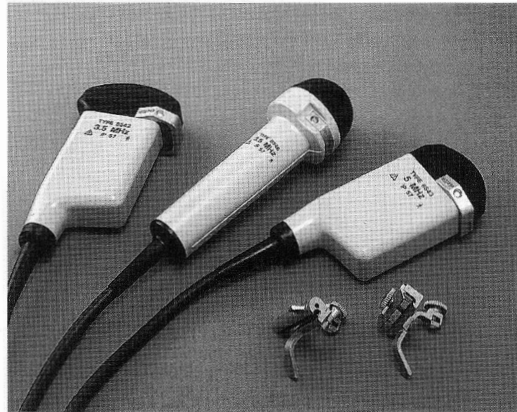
Commercially obtainable ultrasound transducers. The transducers are from left to right: 3.5 MHz convex, linear array, 3.5 MHz annular array, and 5 MHz convex array. All three are used for obtaining real-time B-mode images primarily from the abdomen. The fixtures shown are guides for biopsy needles (photo courtesy of B&K Medical A/S, Denmark).
